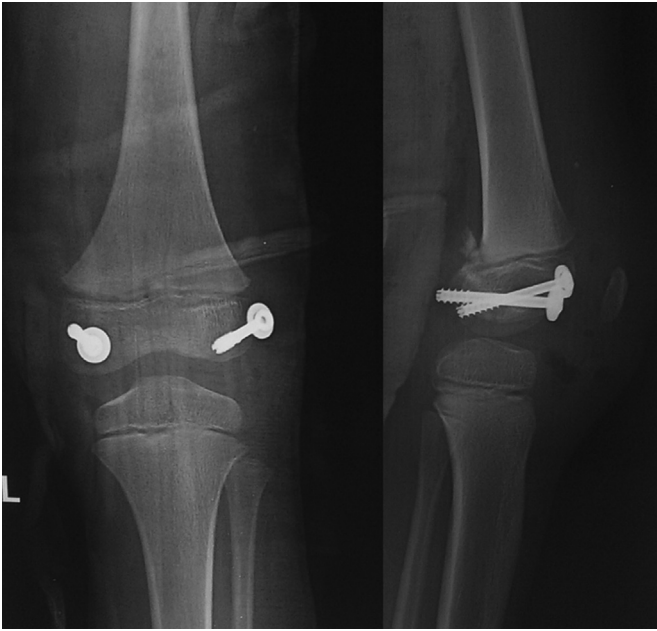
Follow-up radiograph showing fracture union. Patella is lying at normal position.
